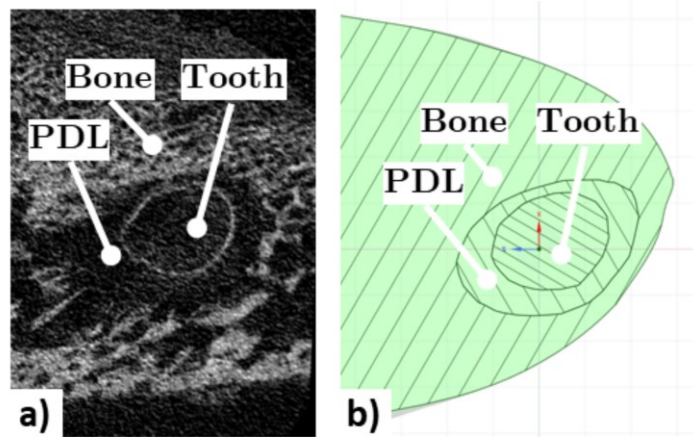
Image demonstrating the apical PDL shape in the mesial root in a)  $\mu$ CT images and b) the FE geometry
